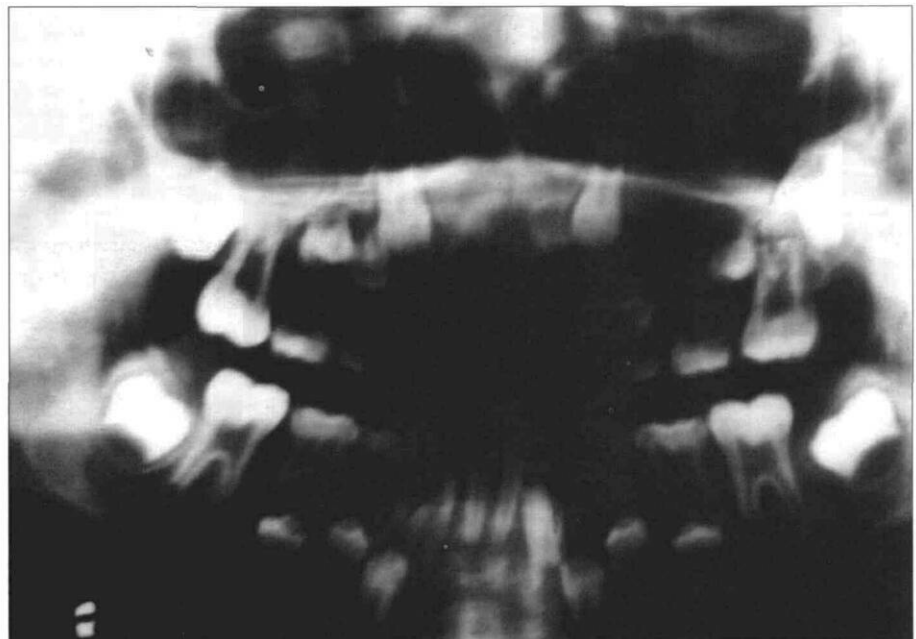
Preoperative panoramic radiograph of pediatric patient scheduled for a maxillectomy procedure. Tumor involving left maxillary sinus and hard palate. Patient is in mixed dentition stage. Evaluation of this patient should include pediatric dental consult.
